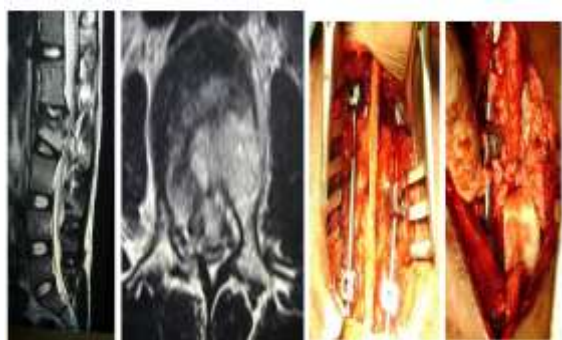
L2 Burst with incomplete neurological deficitFigure 3: L1 Burst fracture without deficit, immediate post opFigure 2: MRI – Cord compression, PLC injury intraoperativeFigure 4: L1 Burst and T12 AWC fracture clinical photo
